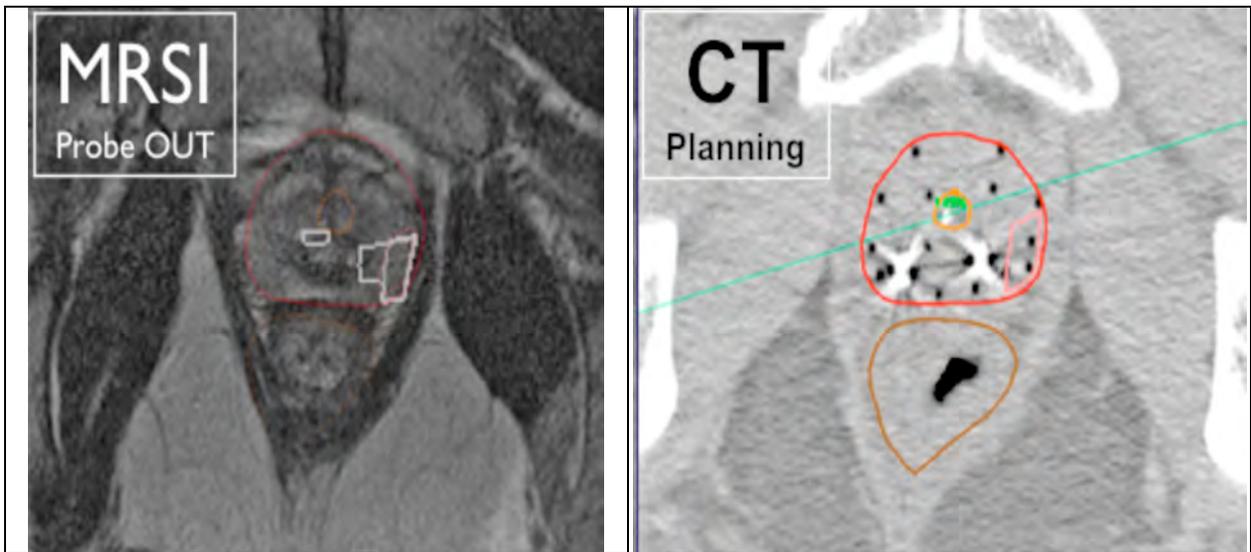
Probe-out MRI image (left) and the MRSI-defined DIL shown on the planning CT (right). The red contour indicates the prostatic margin, green indicates the urethra, brown indicates the rectum, and the pink contour delineates the MRSI-defined DIL.
